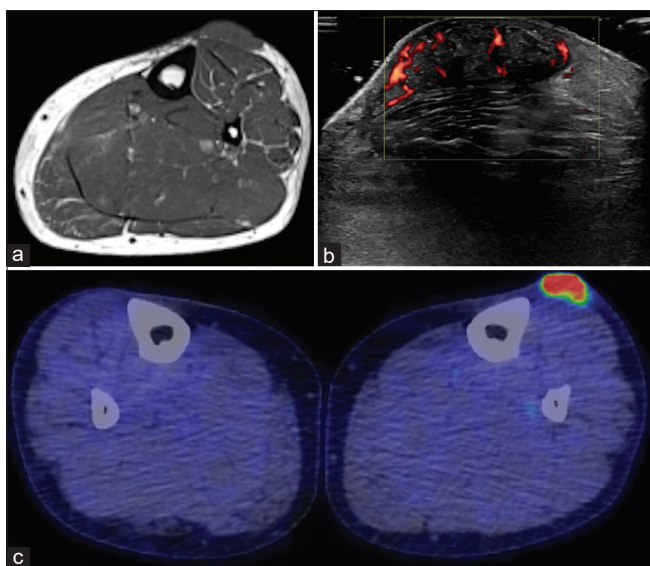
(a) Axial T1 weighted magnetic resonance imaging of the left lower leg, revealing a subcutaneous mass immediately lateral to the left tibial tuberosity. (b) Colour Doppler ultrasound of the mass showing significant peripheral and central neovascularisation. (c) Axial fused staging ^{18}F -fluorodeoxyglucose positron emission tomography computed tomography demonstrating the mass as markedly fluorodeoxyglucose avid (SUVmax = 10.4)
